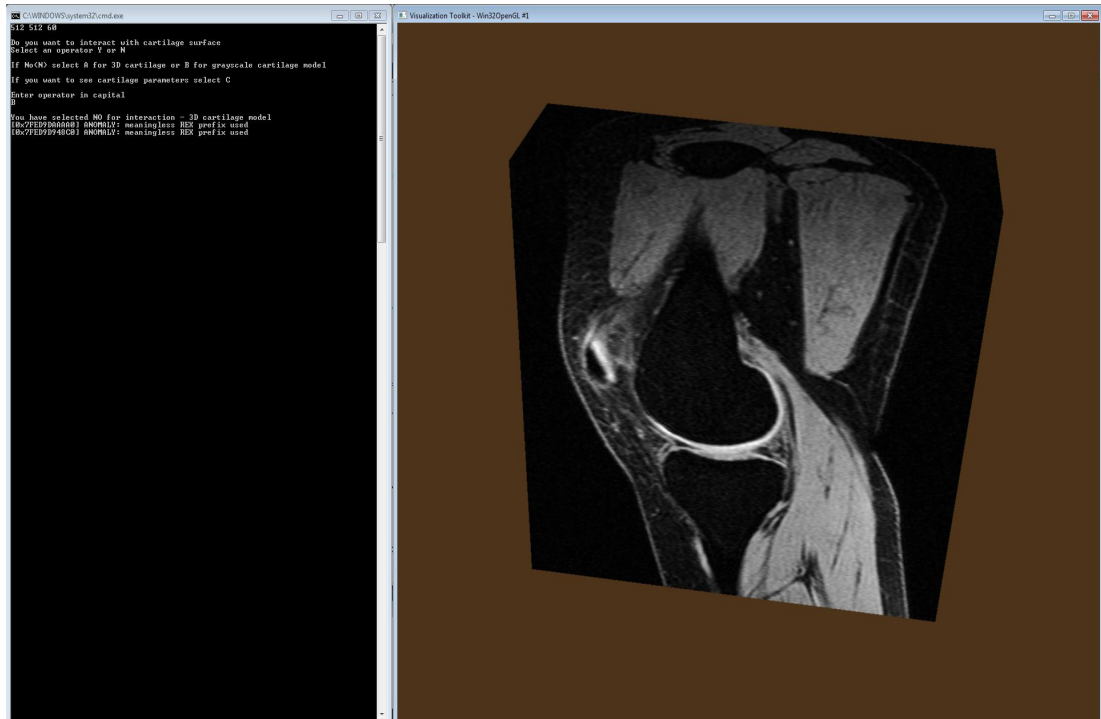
Software framework displaying MRI volume
